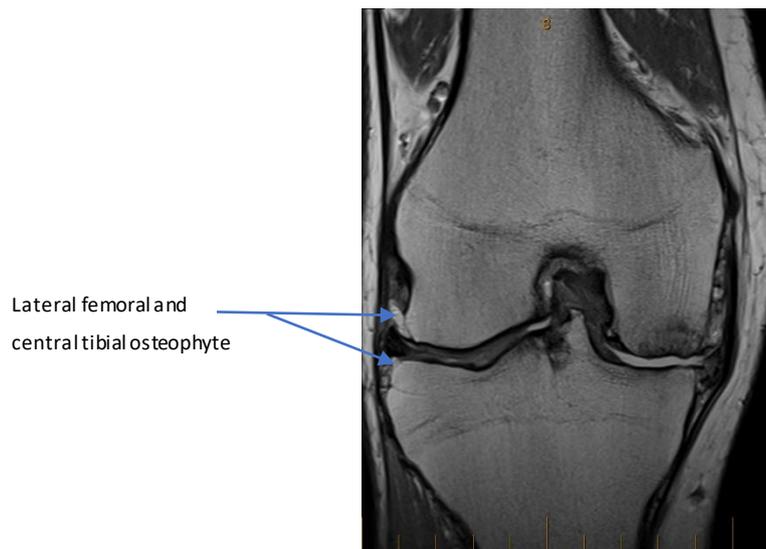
Coronal T1 weighted MRI image showing lateral and central osteophytes (MRI image of a study participant).
